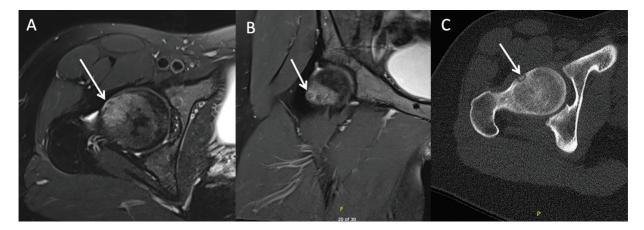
Osteoid osteoma in a 17-year-old female with a 1-year history of hip pain and positive impingement signs. Axial and coronal proton density fat-suppressed image of right hip (A and B) with focal low signal abnormality (*arrows*) in subcortical lateral femoral head with adjoining cortical thickening and bony edema. Computed tomographic axial image (C) shows a typical nidus (*arrow*).
